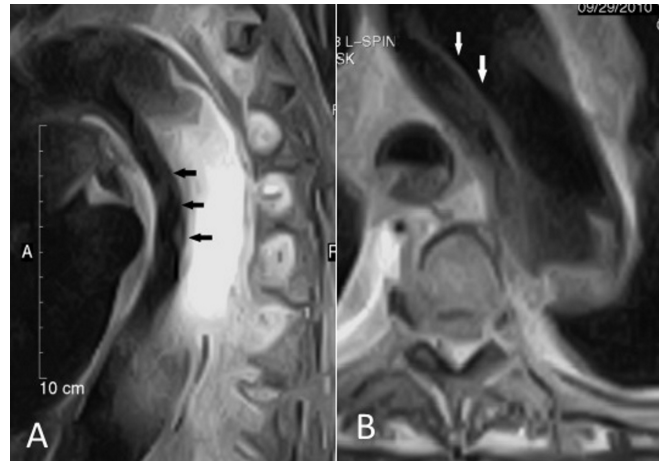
(A) Dissecting flap was observed in the aortic arch and descending aorta in axial MRI (black arrows); (B) sagittal FSE T2 sequences MRI (white arrows).
